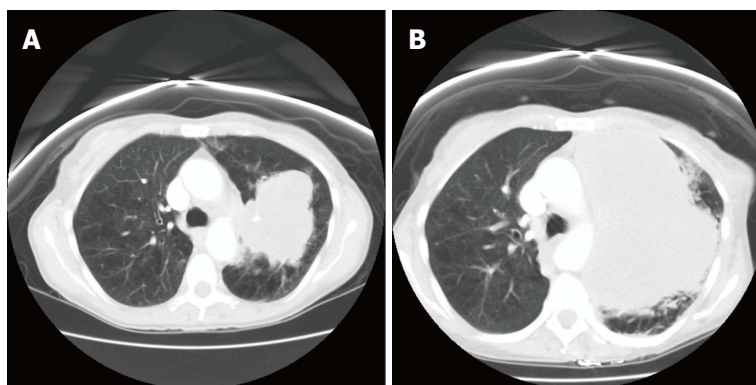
Computed tomography scan of the chest showing the left lung mass. A: At the time of diagnosis; B: Explosive growth of the tumor after two cycles of chemotherapy.
